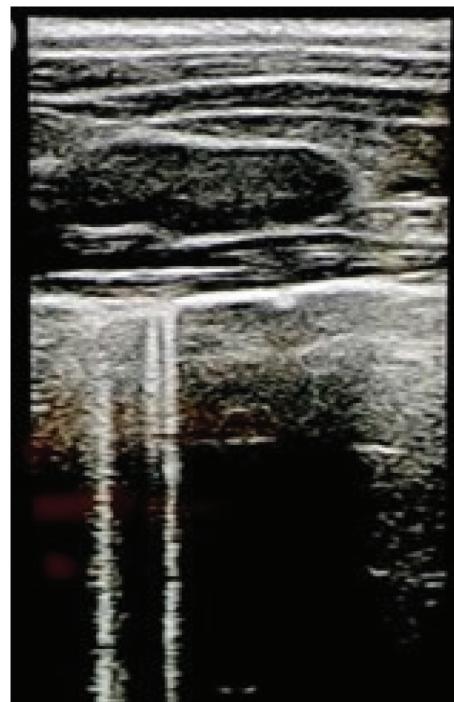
Lung ultrasound at the end of the study, depicting B-lines consistent with increased extravascular lung fluid.
